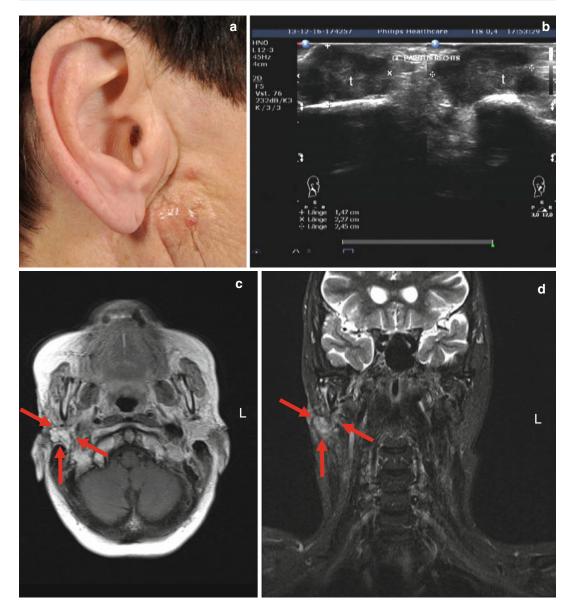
Recurrent adenocarcinoma of the right parotid gland with normal facial function. Primary treatment 2 years ago was parotidectomy and postoperative radio-therapy. (a) The tumor became obvious by the skin infiltration (*arrows*). (b) Ultrasonography showing the recurrent tumor (*t*). (c) Axial MRI showing in contrast to
